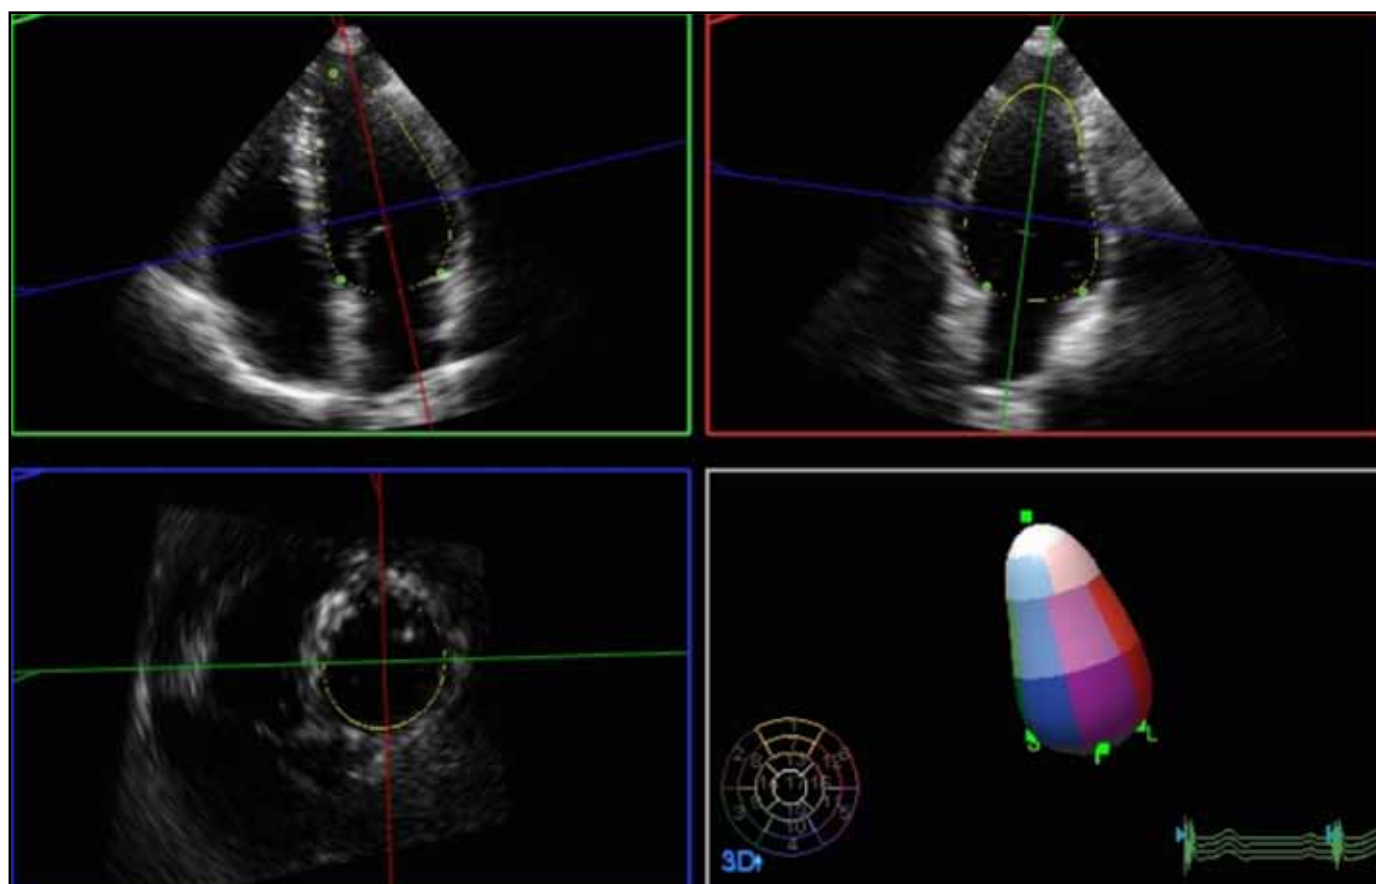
Three-dimensional echocardiography captures an entire heart volume in motion over time. Slices from any angle may be reconstructed as can a three-dimensional shell, representing the left ventricular volume.
